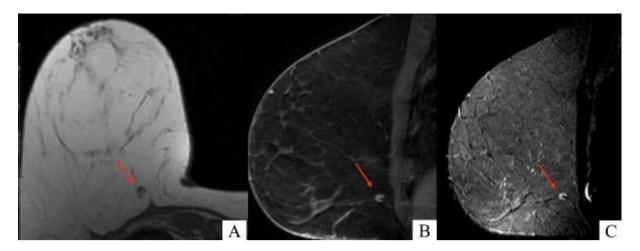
(i): Normal IMLN MRI imaging features (A) T_1 weighted images demonstrates a circumscribed reniform mass with hilar fat signal. (B) IMLN cortex showing homogeneous enhancement on T1 post-contrast study and, (C) high signal at T_2 weighted images
